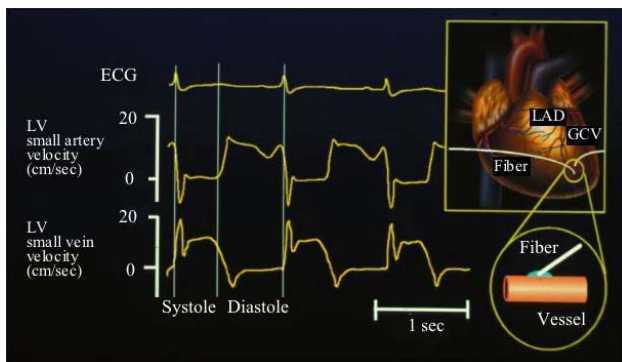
Coronary arterial and venous blood velocity waveforms measured by an optical fiber sensor of laser Doppler velocimeter. The fiber sensor was fixed by cyanoacrylate adhesive on distal small artery and vein to evaluate myocardial inflow and outflow. Note the phase difference between arterial inflow and venous outflow; that is, diastolic versus systolic preponderance.
